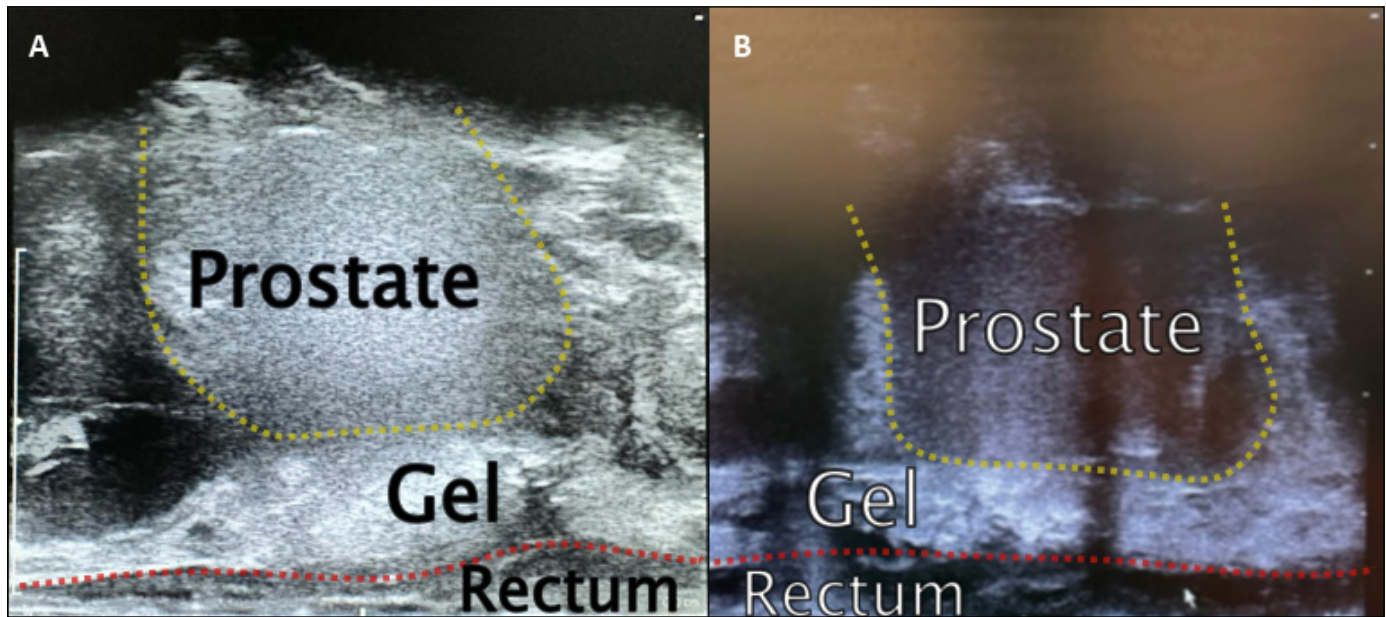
A) Sagittal trans-rectal ultrasound image after normal gel placement in the anterior perirectal space. B) Sagittal trans-rectal ultrasound image showing a slightly reduced amount of recto-prostatic separation in our patient with circumferential echogenic material.
